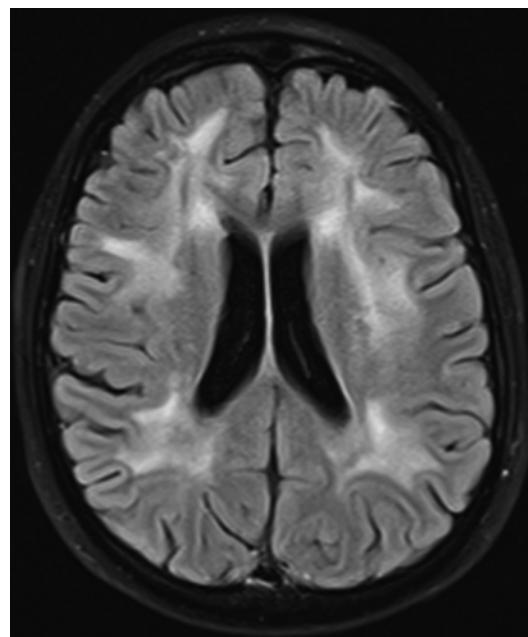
Leukencephalopathy. Confluting FLAIR hyperintensities in the white matter at the level of the centrum semiovale (LEP grade III) after combined treatment of a disseminated medulloblastoma. Note also a moderate atrophy with mildly enlarged ventricles and sulci
